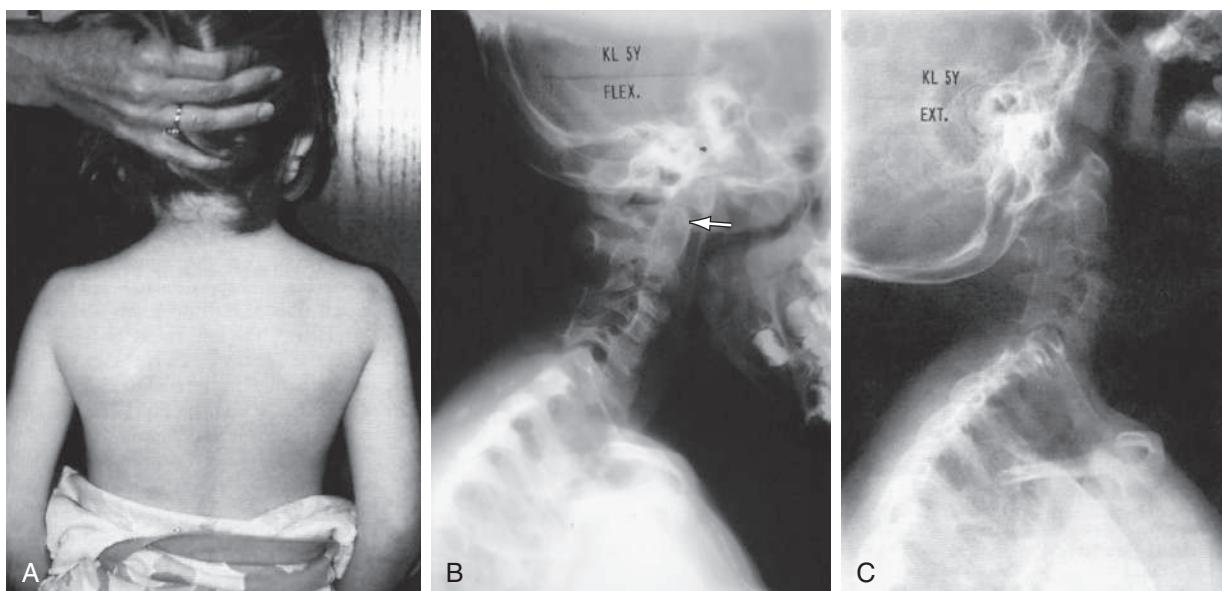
Clinical picture of a 5-yr-old with Klippel-Feil syndrome. A, Note short neck and low hairline. B and C, Radiographs of the cervical spine (B, flexion; C, extension) demonstrate congenital fusion and evidence of spinal instability (arrow). (From Drummond DS. Pediatric cervical instability. In: Weisel SE, Boden DS, Wisnecki RI, eds. Seminars in Spine Surgery. Philadelphia: WB Saunders; 1996:292-309.)
